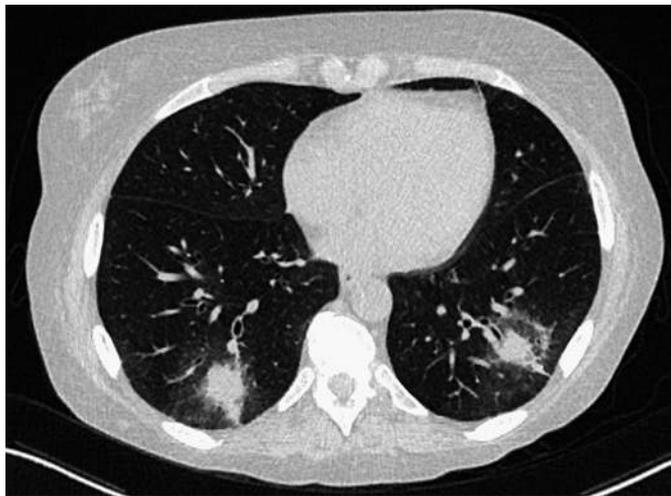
Cavitory nodular pneumonia caused by *Aspergillus*. A 34-year-old woman undergoing induction chemotherapy for newly diagnosed acute myeloid leukemia presents with persistent neutropenic fevers and cough productive of scant hemoptysis. Sputum cultures are negative, but serum galactomannan antigen is markedly elevated, highly suggestive of *Aspergillus* infection. Computed tomography reveals multicentric cavitory nodules, some of which have a halo of ground glass opacity surrounding them, findings that are classic for invasive pulmonary aspergillosis.
